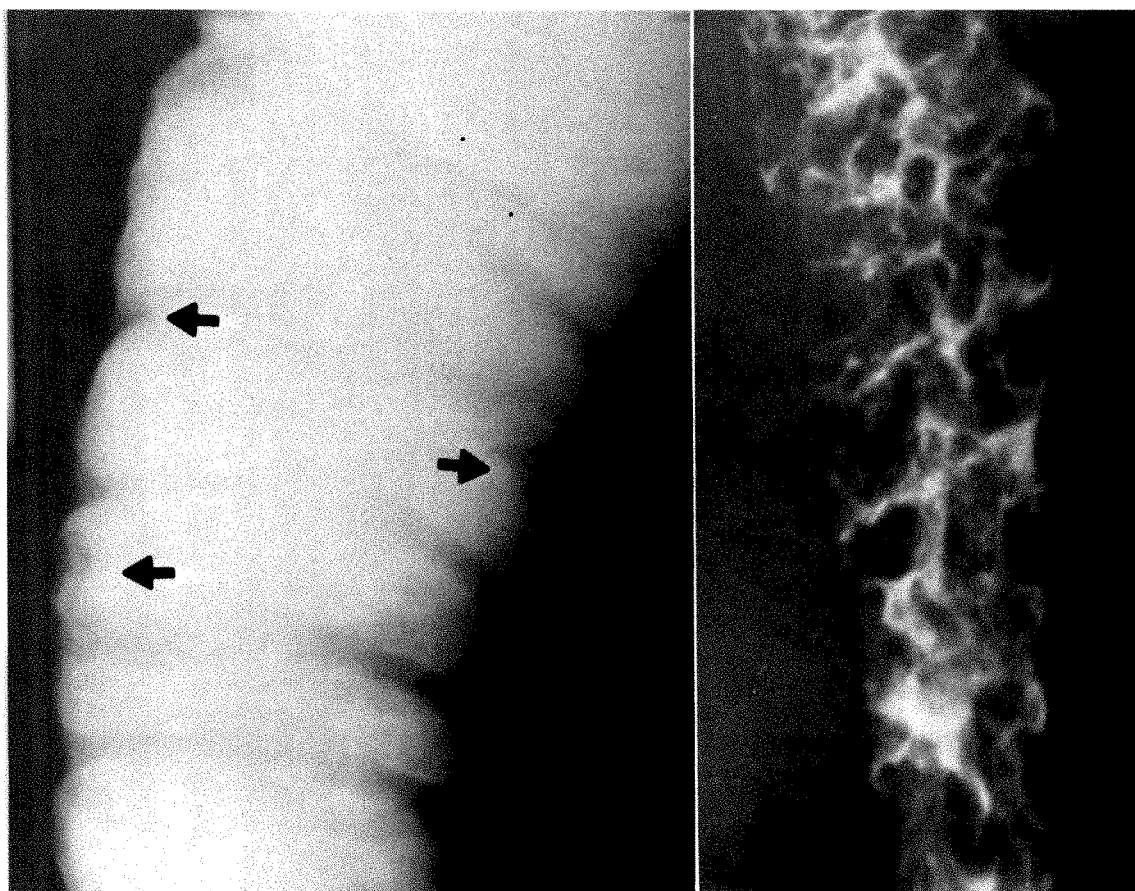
Roentgenograms of segment of descending colon before and after evacuation. Small filling defects, faintly seen in filled phase (arrows), are striking on postevacuation film. Such nodules present throughout colon.
